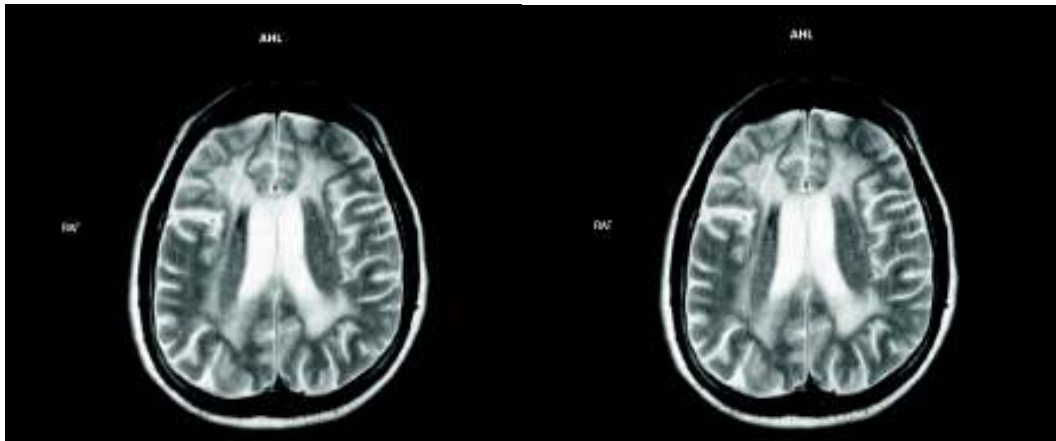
T2 FLAIR hyperintense diffuse lesions in the frontal subcortical deep white matter, periventricular white matter, and corpus callosum on MRI
